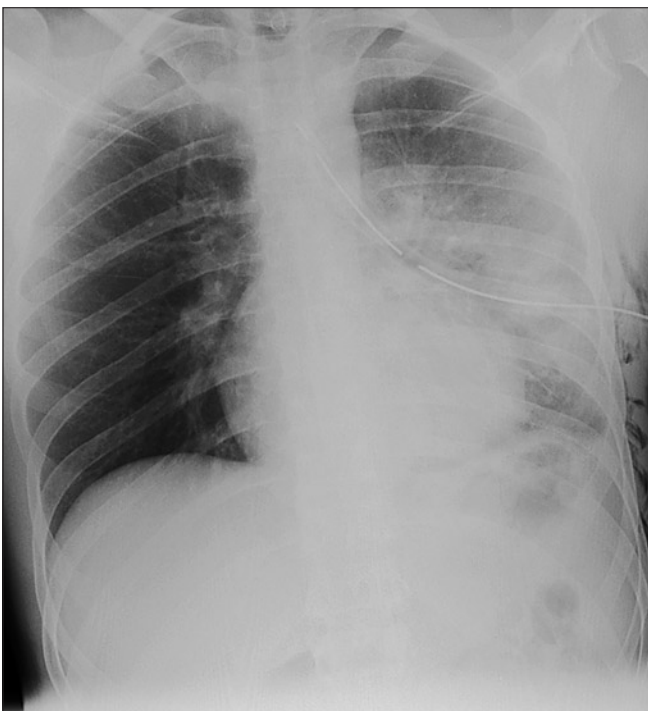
Tension pneumothorax after decompression using drainage – chest X-ray
